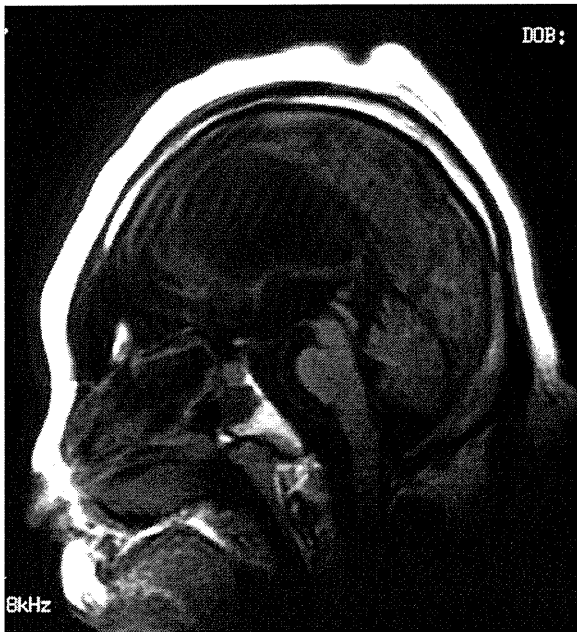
MRI at 32 years of age. Sagittal T1-weighted image shows, the brain stem and cerebellum are spared.
